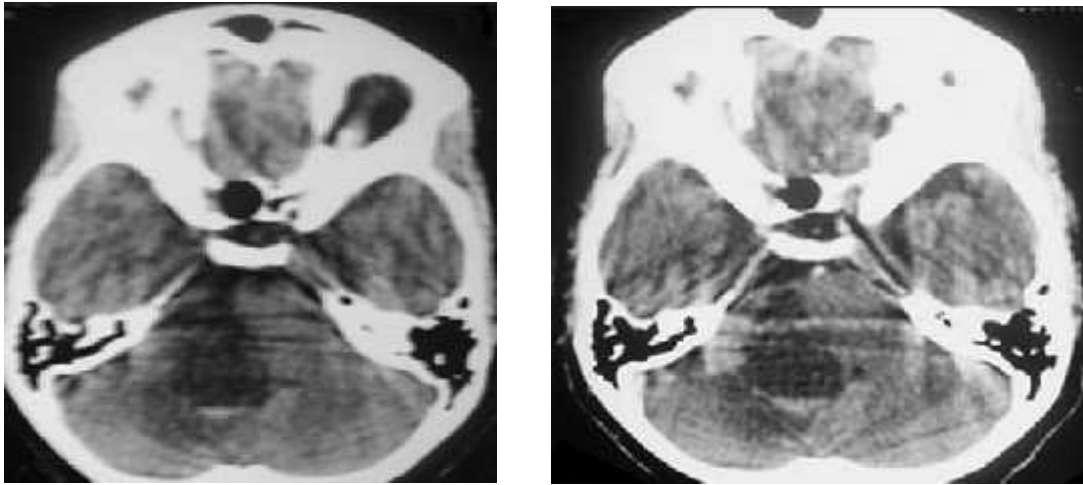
HRCT axial brain window shows well defined mass lesion with few few hypodense cystic components noted in the region of right cerebellopontine angle causing widening of porus acusticus and showing heterogenous enhancement of solid components on post contrast study.
